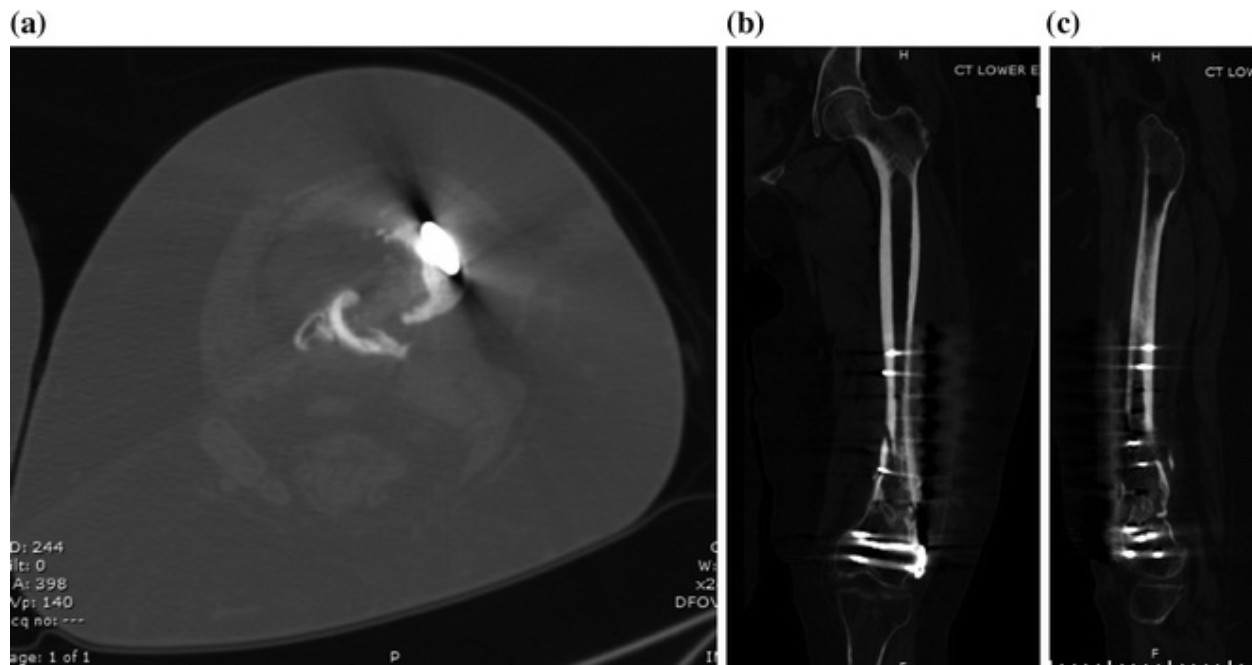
Computed tomography scan images showing the nonunion: a axial image showing lack of bone, b coronal image showing the varus and nonunion, c sagittal image showing the recurvatum deformity and nonunion
